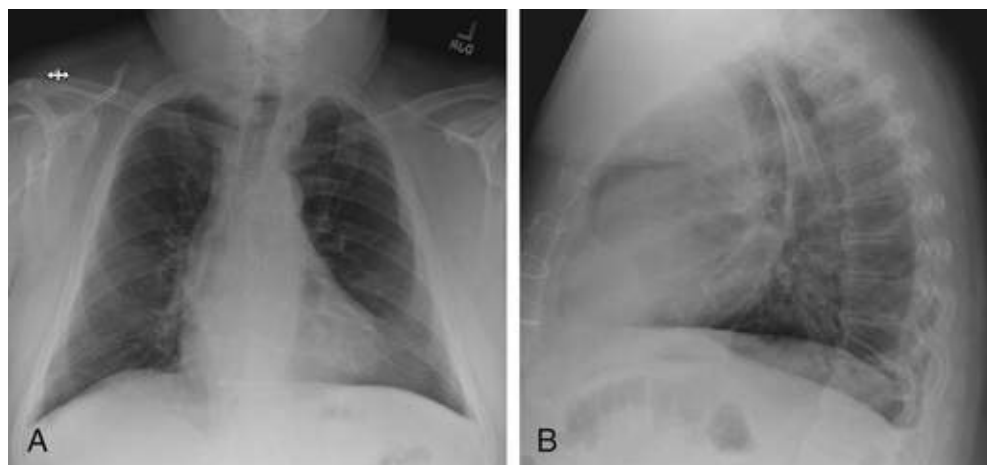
Costophrenic angles (CPAs) on the lateral view. Standard PA (A) and lateral (B) radiographs of the same patient shown in eFig. 15.2 were obtained the previous day and show no blunting of the right lateral CPA on the PA view, with blunting of the right posterior CPA on the lateral view. The posterior right CPA is located farther behind the spine than the posterior left CPA due to magnification of the right-sided structures, which are located farther from the image recording surface.
